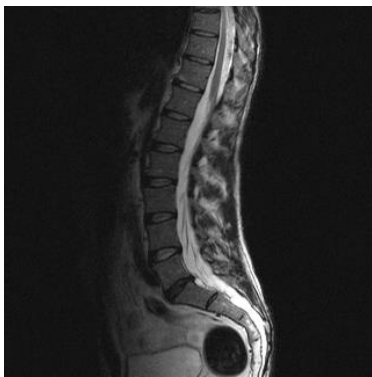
MRI of the lumbosacral spine: sagittal plane; right-sided sacral S2 and S3 perineural cysts, the largest located at the right S2 nerve root.
